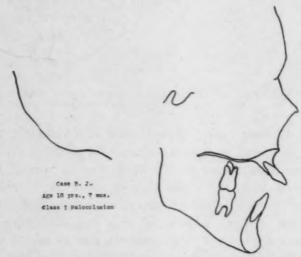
Tracings of lateral cephalometric x-ray of patient with Class II, Division 1 or Class I mutilated occlusion. Note the curvature of the nasal floor.
